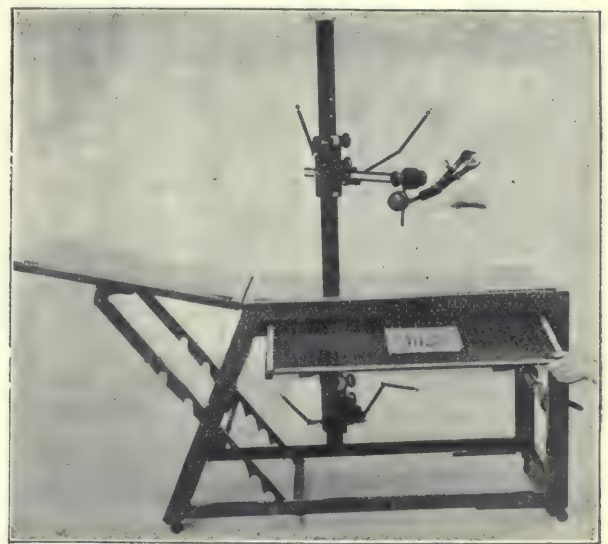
Author's X-Ray Table (Opened), showing one of the two plate shelves.
